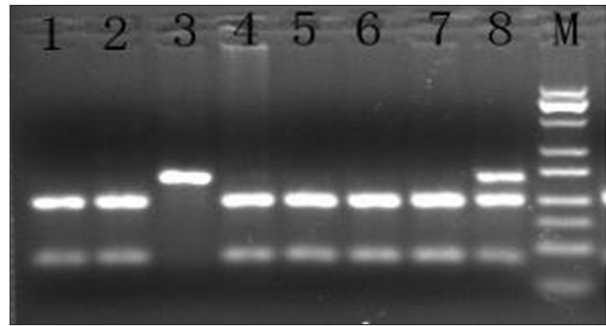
The *GSTP1* gene rs1695 polymorphism in PCR-RFLP electrophoresis map. M – Marker; 1, 2, 4, 5, 6, 7 – CC; 8 – CT; 3 – TT.
